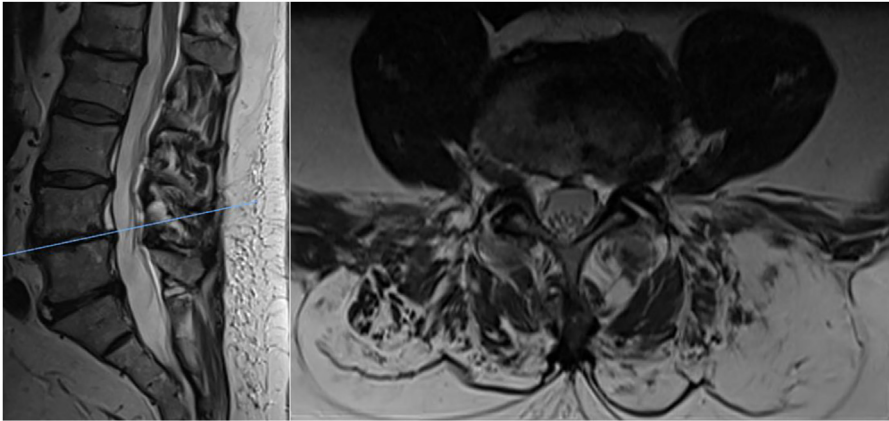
MR imaging of corridor window; MR sagittal and axial cuts of a patient who underwent ATP fusion to L4-5. There is lateral listhesis at L4-5. There is vacuum change in L4-5 disc space, as well as up-down foraminal stenosis at L4-5 (not pictured on parasagittal views) as well as auto-fusion at L5-S1. There are no vessels obstructing the corridor to access the L4-5 disc space. This patient underwent successful fusion with percutaneous posterior fusion.
